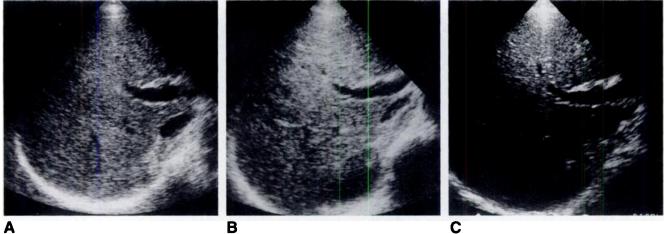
A, Longitudinal sonogram obtained at level of portal vein before contrast administration shows a large hypoechoic lesion (*arrows*). B, Center of lesion is more echogenic on sonogram obtained immediately after infusion (*arrow*). C, Echogenic central focus grew in the next 24 hr, leaving a hypoechoic rim (*arrowheads*) and giving lesion a targetlike appearance.
